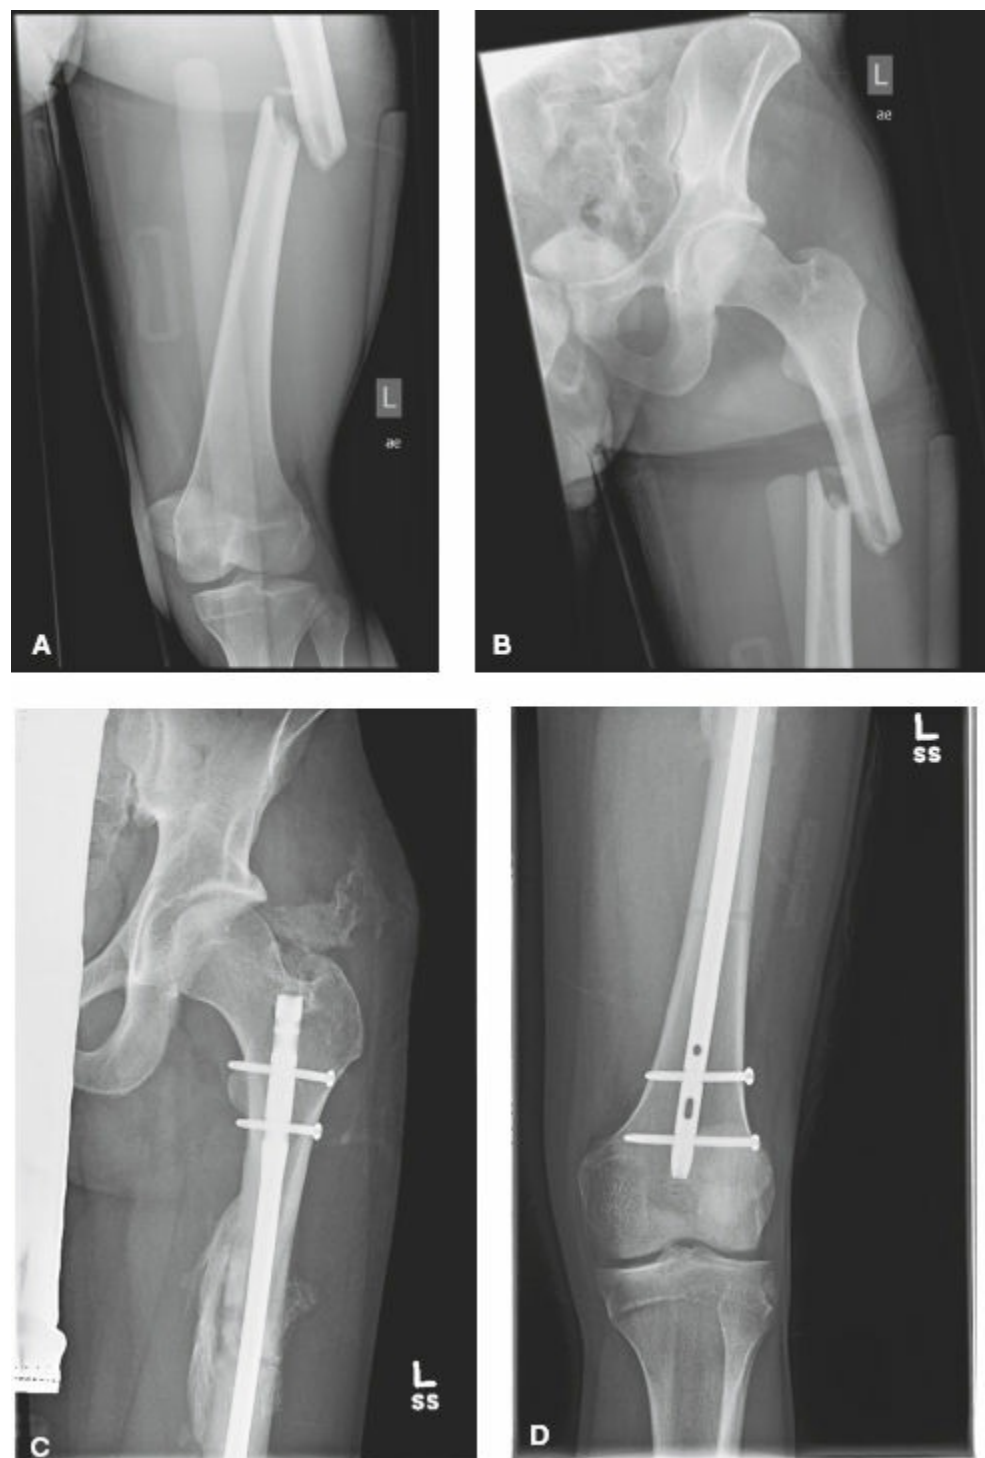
Assessment and surgical management of a diaphyseal fracture of the femur. A,B: Anteroposterior x-rays of a diaphyseal femur fracture C,D: Reamed fully locked intramedullary nailing of a diaphyseal femur fracture showing progressive healing.
